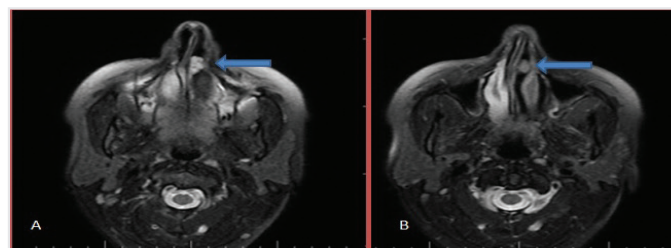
Axial T1 (A) and T2 (B) magnetic resonance images
